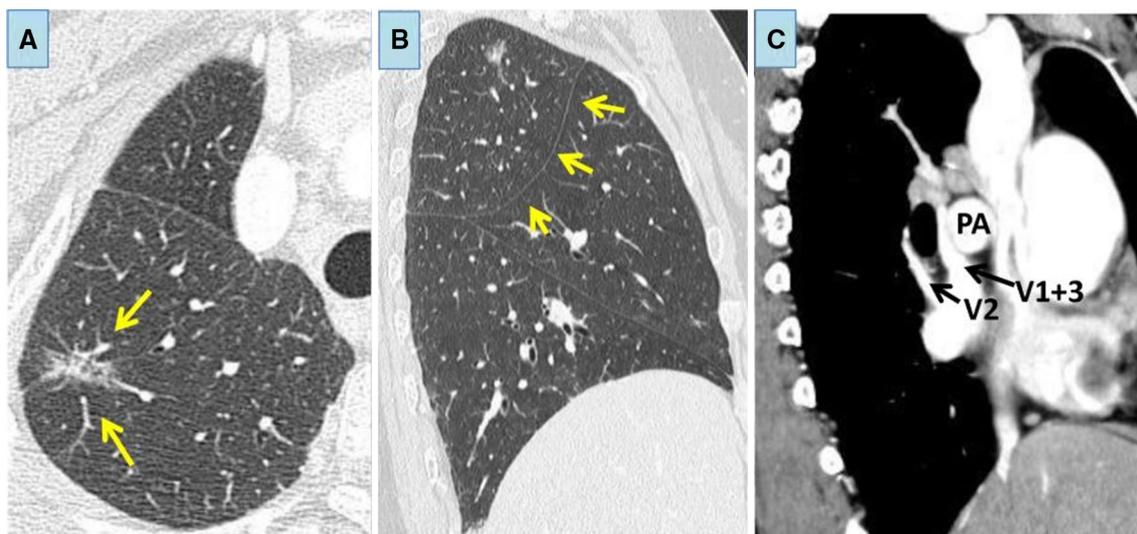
a Partly solid ground-grass nodule found in the right upper lobe. b Sagittal computed tomography image showing that the right upper lobe was relatively small because the middle lobe was located
